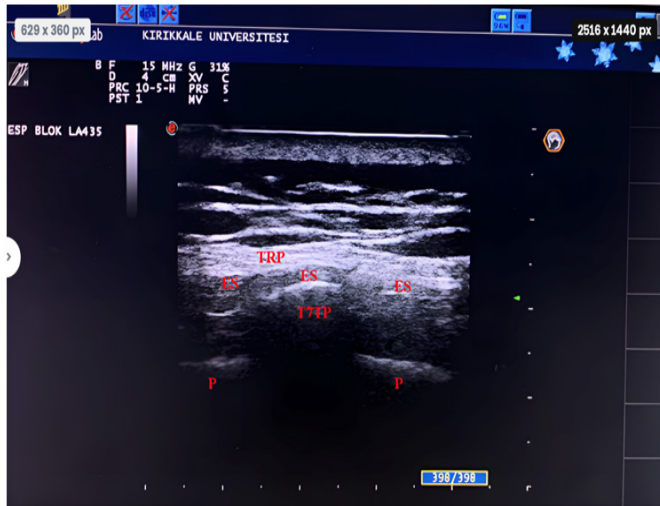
Ultrasonography image of the erector spinae plane block
